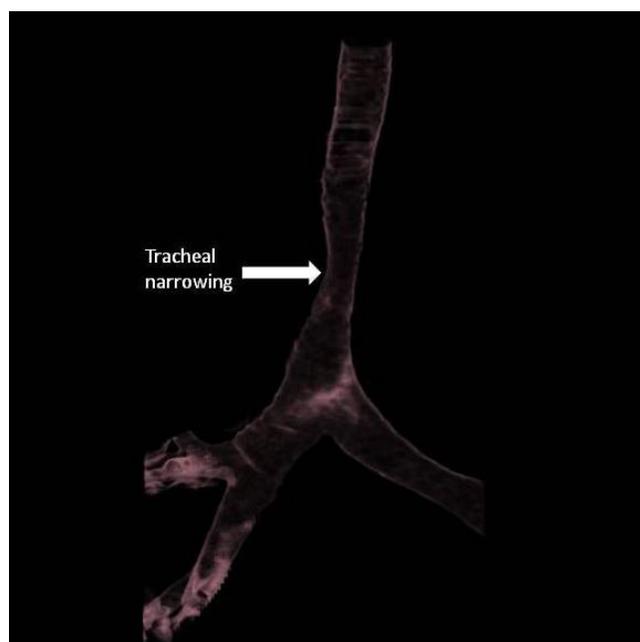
Three dimensional reconstructed CT image makes it easier to see the narrowing of the tracheobronchial tree
